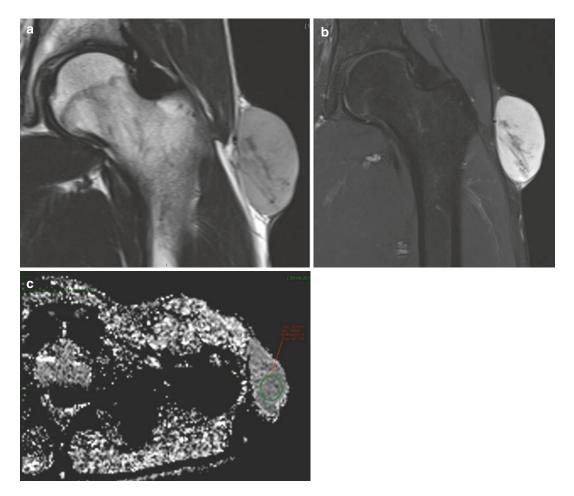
(a–c) Dermatofibrosarcoma protuberans of the left thigh. (a) Coronal fast spin-echo T2 MR image shows oval subcutaneous soft tissue mass. (b) Coronal fat-saturated T1 MR image after intravenous injection of gadolinium contrast medium shows intense enhancement
